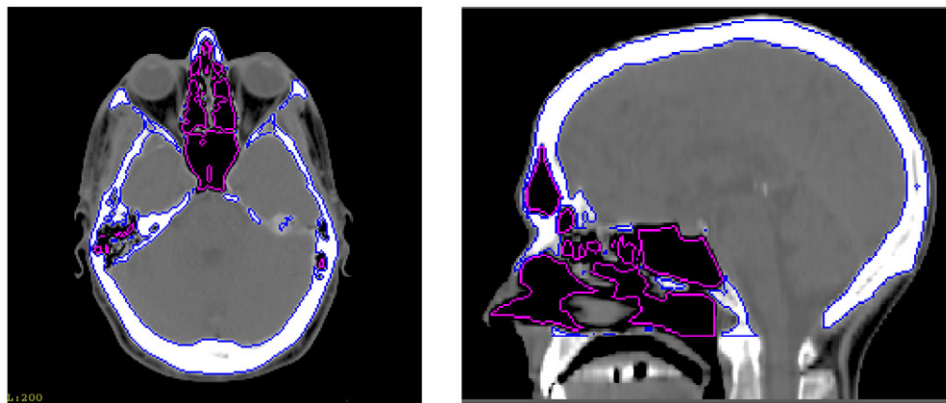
‘True’ air (magenta) and bone (blue) regions generated from CT images using thresholds of < -400 HU and > 200 HU, respectively.
